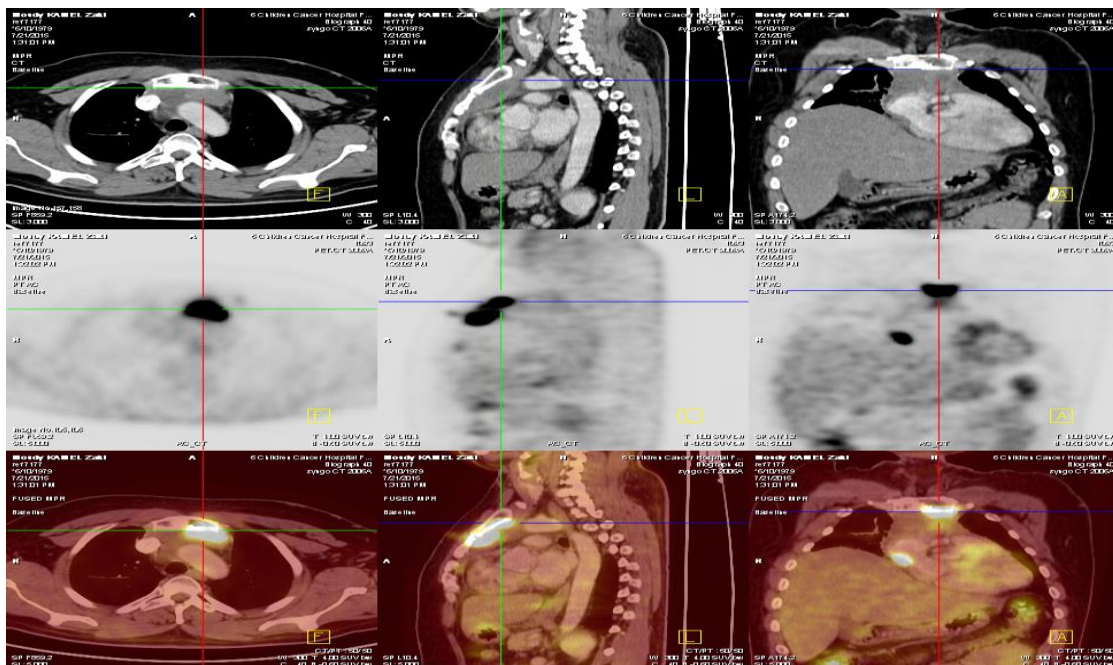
B): Follow up after 3 months without treatment, there was disease progression in the size of the mass with high FDG uptake in delayed scan SUV max~15.5 with appearance of other new lesions that indicated disease progression.
